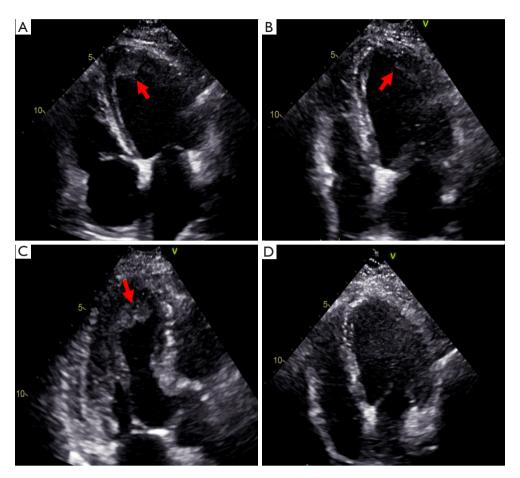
Echocardiography images after imatinib treatment. (A) Apical 4-chamber view after 1 month of treatment, showed that the left ventricular thrombus (arrow) was slightly smaller than before. (B) Apical 4-chamber view after 6 months of treatment, showed a thrombus (arrow) at the apex of the left ventricular lateral wall, significantly smaller than previous one. (C) 3-chamber cardiac view after 6 months of treatment, showed local thickening of the endocardium (arrow) at the apex and significant reduction of thrombosis. (D) Apical 4-chamber view after 1 year of treatment, showing that the thrombus at the apex has completely disappeared.
